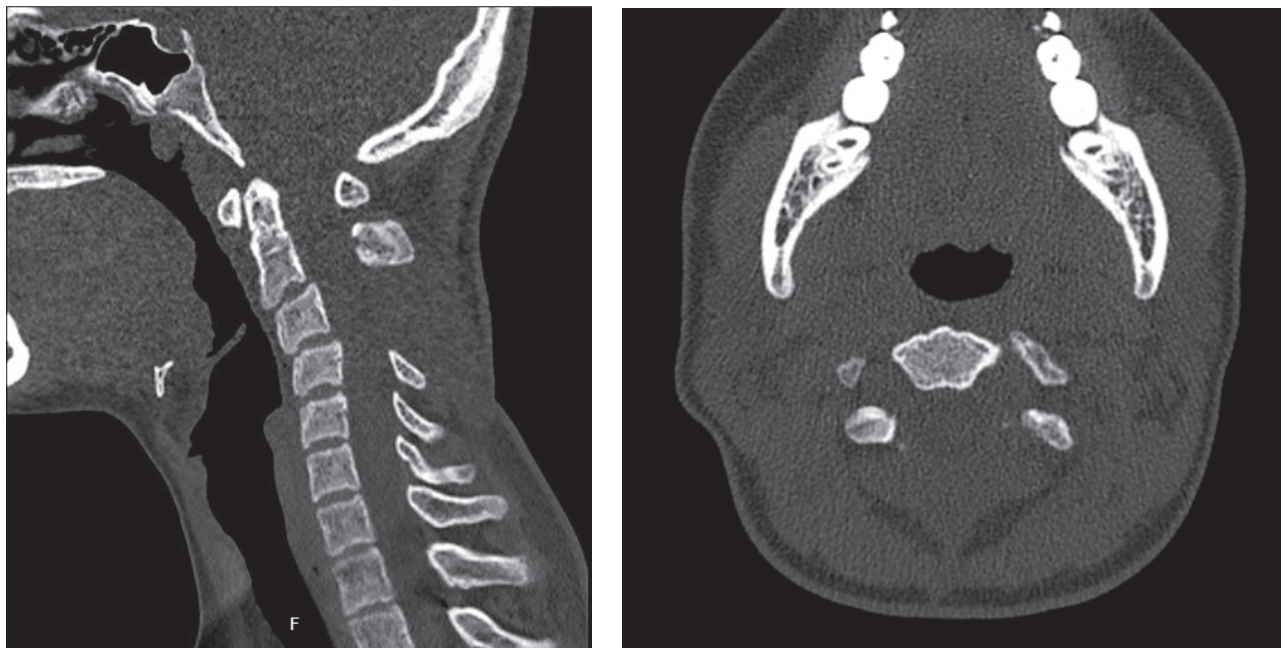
a) Early postoperative cervical spine CT scan in sagittal plane after the resection of aneurysmal bone cyst (ABC) b) Cervical spine CT scan in axial plane demonstrating resection of bone lesion.
